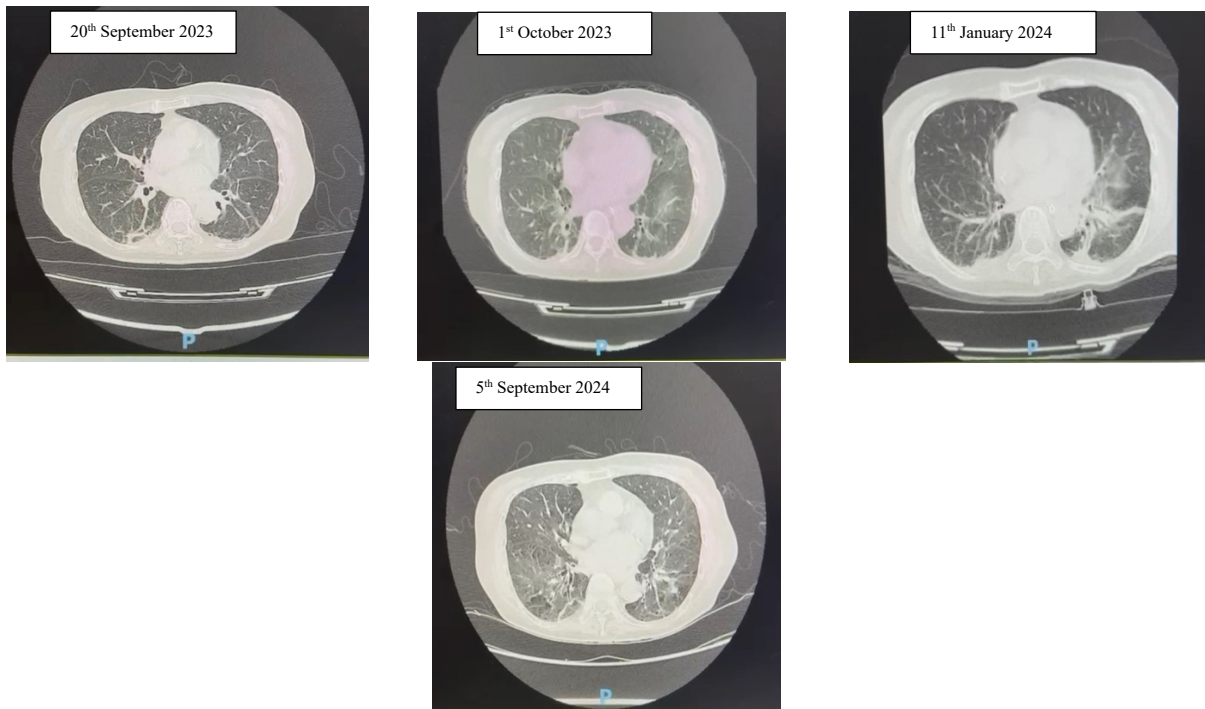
Serial high-resolution computed tomography showing a slight increase in bilateral lung fibrosis in the lungs, mainly at the posterior lower lobes, associated with mild traction bronchiectasis and subsegmental plate atelectasis at the medial lobes bilaterally.
